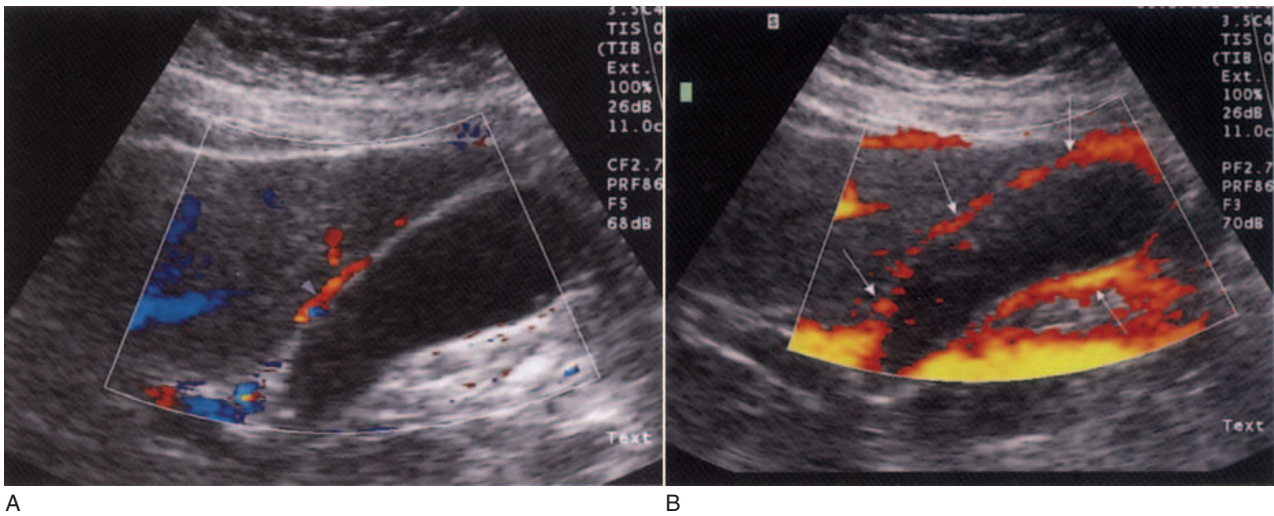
Normal gallbladder wall vascularity. (A) In a normal gallbladder, colour Doppler can demonstrate the cystic artery (arrowhead) but does not demonstrate flow near the fundus. (B) Power Doppler is more sensitive and can demonstrate flow throughout the wall (arrows) in a normal gallbladder; this must not be mistaken for hyperaemia.
